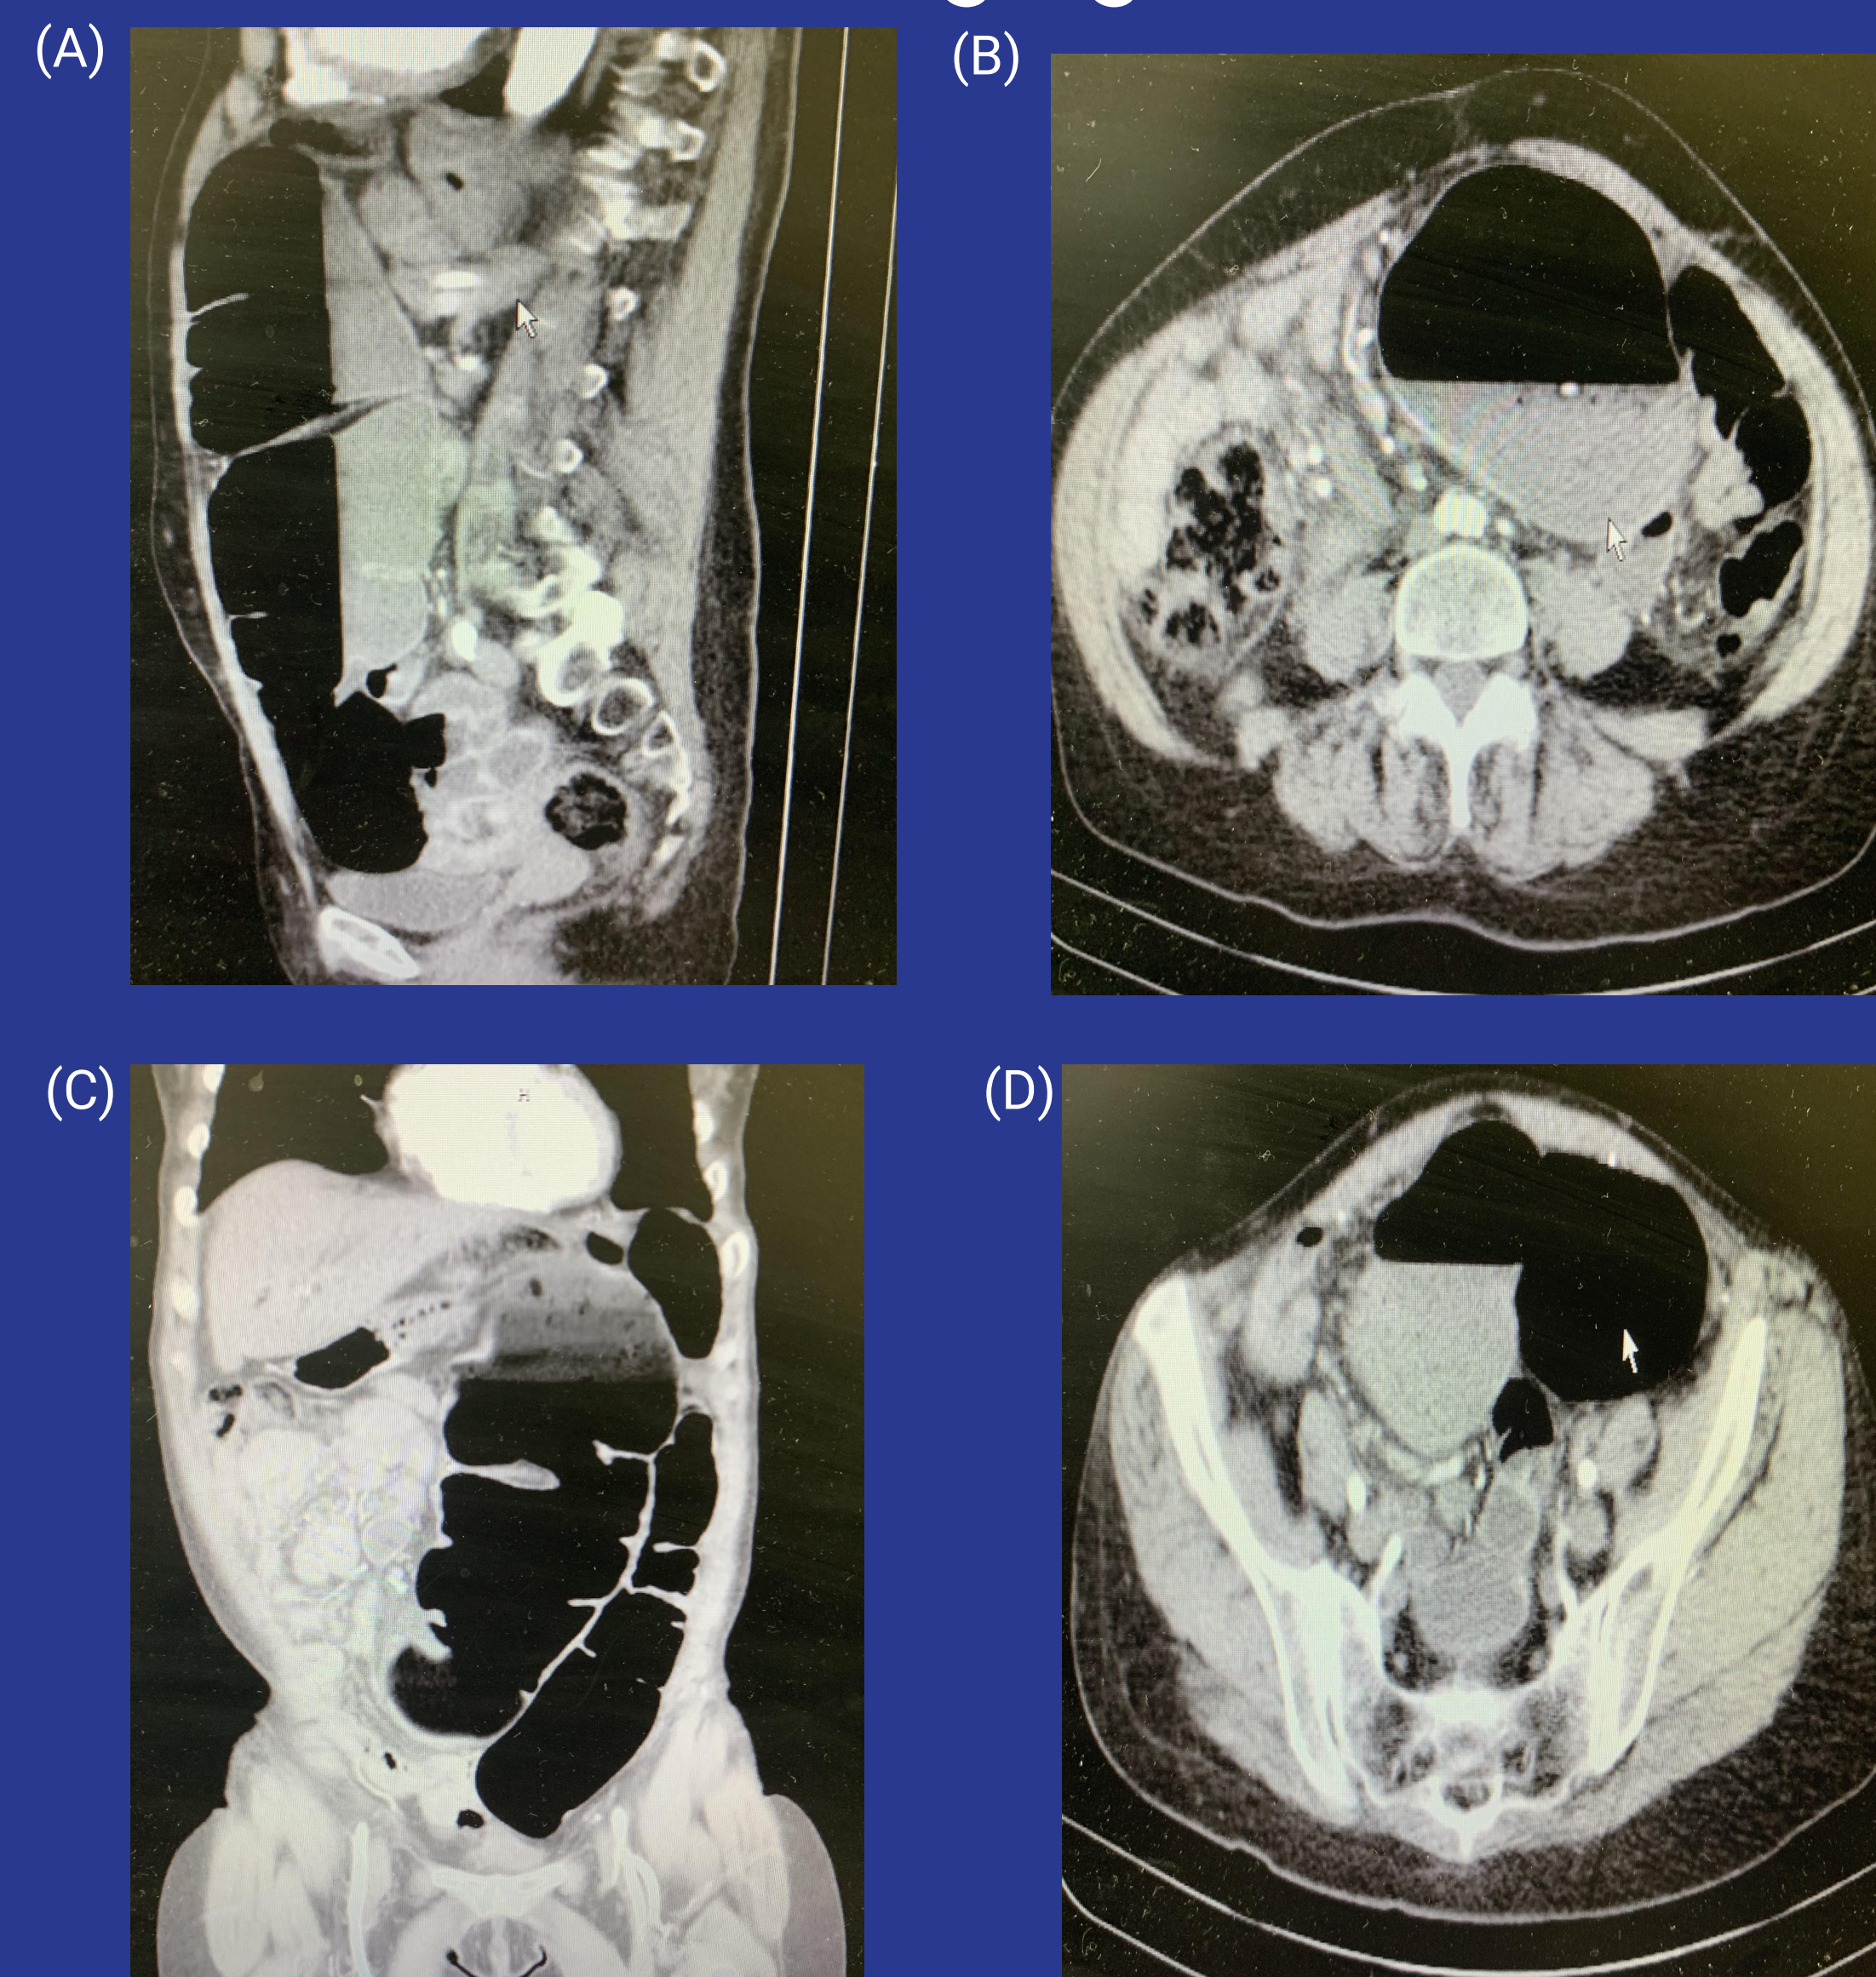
(A) CT Abdomen/Pelvis Sagittal view diffuse dilation of sigmoid and transverse colon. (B) CT Abdomen /Pelvis Axial view showing dilations of sigmoid colon, mild to moderate distention of cecum. (C) CT Abdomen/Pelvis Coronal view showing “Coffee Bean” sign, indicating sigmoid volvulus (D) CT Abdomen pelvis Axial view showing additional sigmoid distention, sigmoid volvulus.
